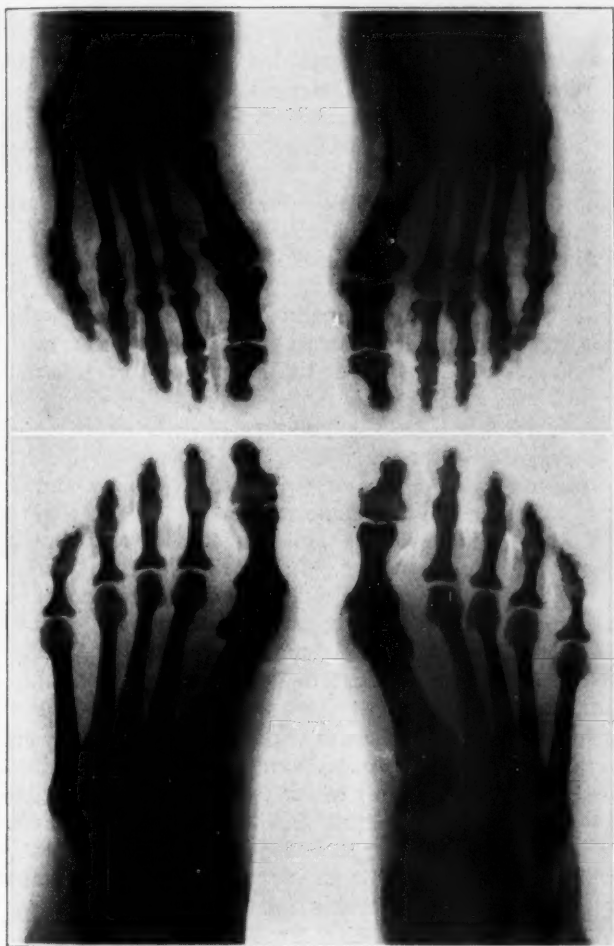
The upper roentgenogram shows the brother's feet, with phalangeal synostosis and budding, and the lower, the sister's feet, with symmetrical budding and phalanges of the Telford-Smith type.
